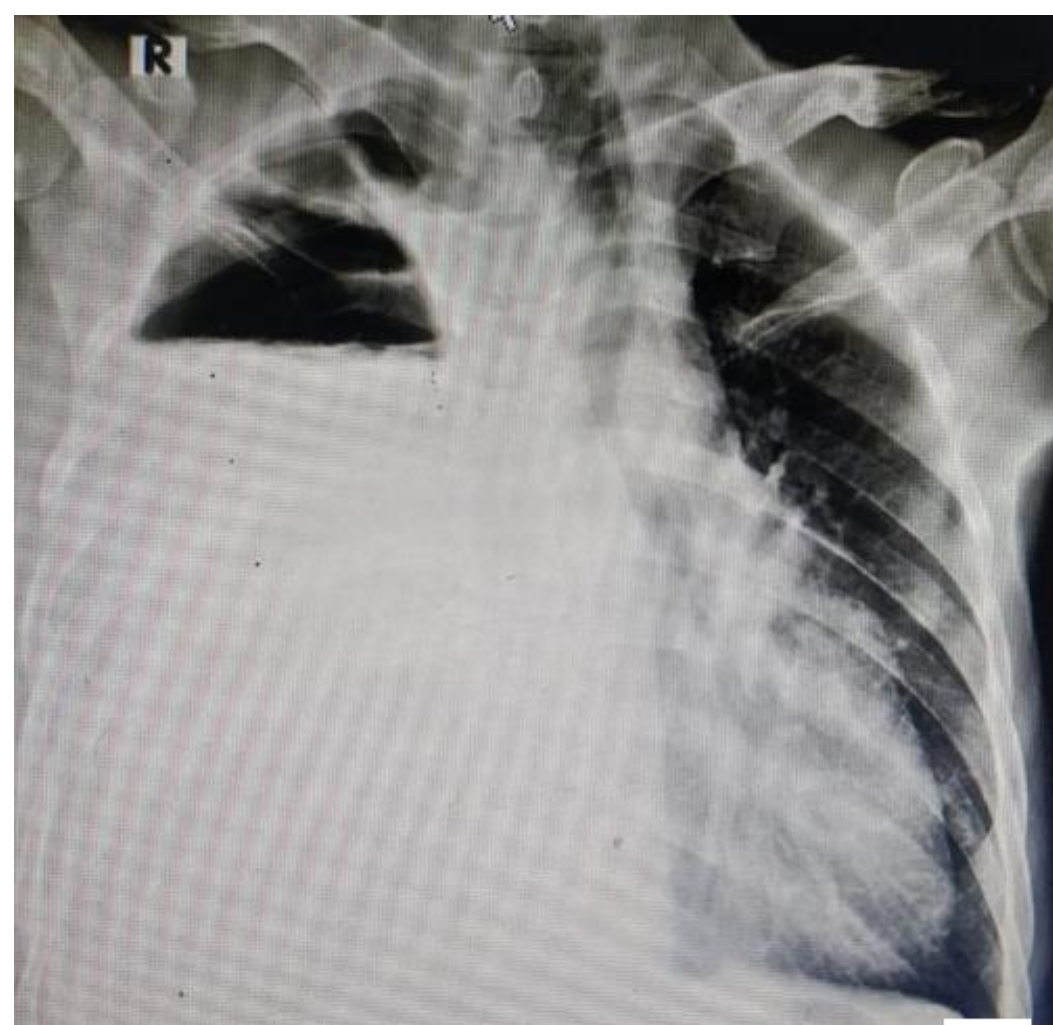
Chest x-ray showed hydropneumothorax on the right side.
